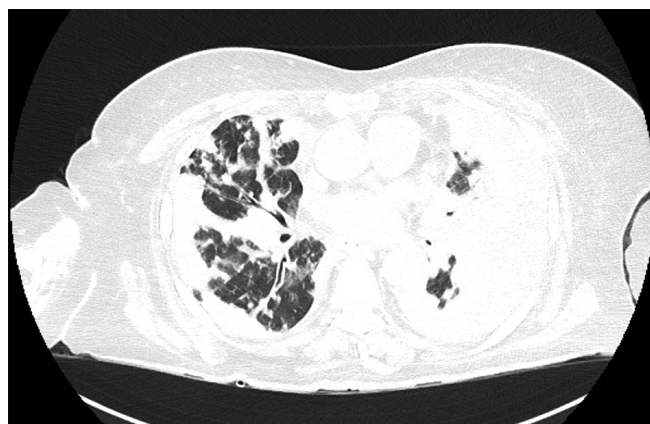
Thoracic CT scan at final presentation. Marked progression and confluence of bilateral consolidations with increased pleural effusion.
